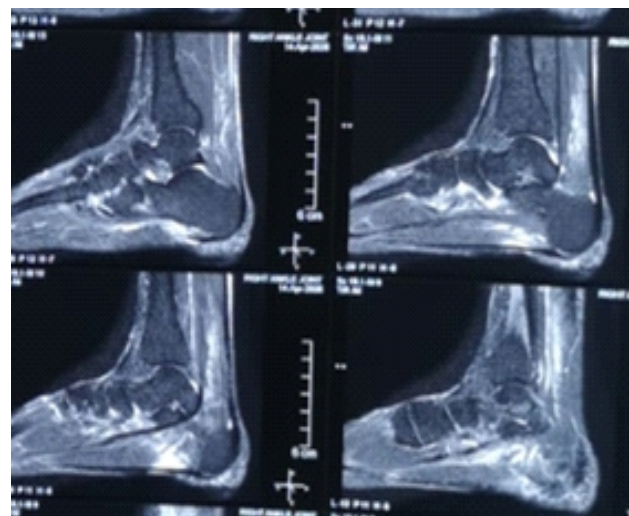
Magnetic resonance imaging showing thick plantar fascia.
